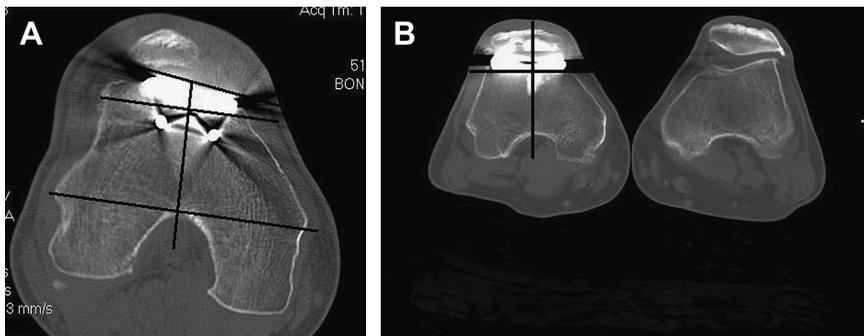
(A) Axial CT scan of an inlay-style implant demonstrating internal rotation relative to the anteroposterior axis of the distal femur, resulting in lateral patellar catching and subluxation. (B) Axial CT scan of an onlay style trochlear prosthesis showing rotation perpendicular to the AP axis of the femur.
